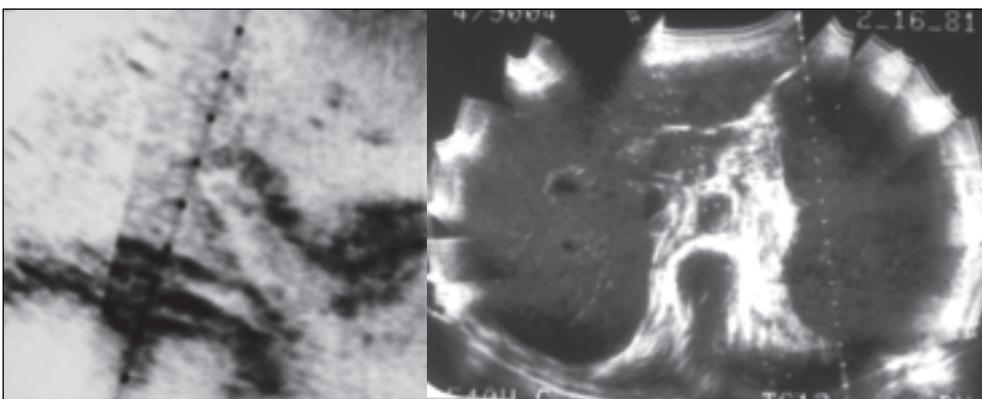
Ultrasound in the late 70s. Ultrasound regularly revealed previously unseen pathology such as portal vein thrombosis (left). In the early 80s ultrasound images often were more revealing than the body CT images of the time.
